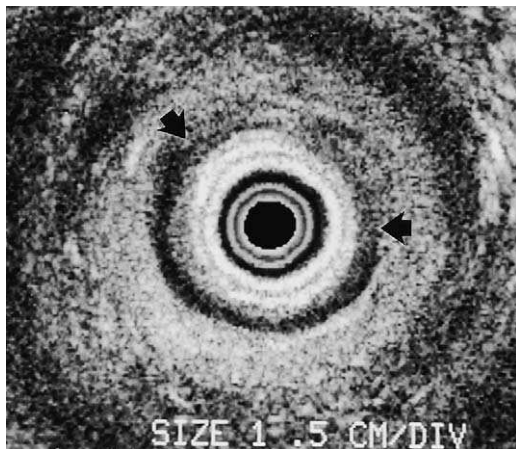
Axial image obtained during a transrectal ultrasound of a 58-year-old woman with fecal incontinence. The internal anal sphincter becomes increasingly hyperechoic and thin (between arrows), which indicates damage to the anterior portion, with a tear at the midline.
